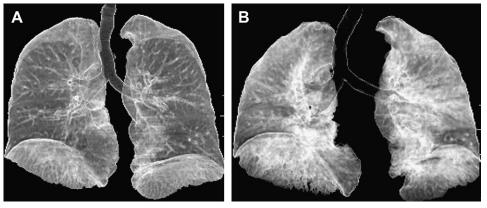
A 70-year-old woman with a history of bronchial asthma. (*A*, *B*) The reconstructed images with volume rendering of the posterior two-thirds of the lungs at end-inspiration and end-expiration using an ADW workstation. Volume and attenuation changes after expiration are visually displayed in a 3-dimensional fashion, providing easy recognition of air trapping. There are marked changes in the configuration of the airway conducting to the areas of air trapping. (*From* Nishino M, Boiselle PM, Copeland JF, et al. Value of volumetric data acquisition in expiratory high-resolution CT of the lung. J Comput Assist Tomogr 2004;28:209–14; with permission.) ADW, Advanced Development Workstation.
